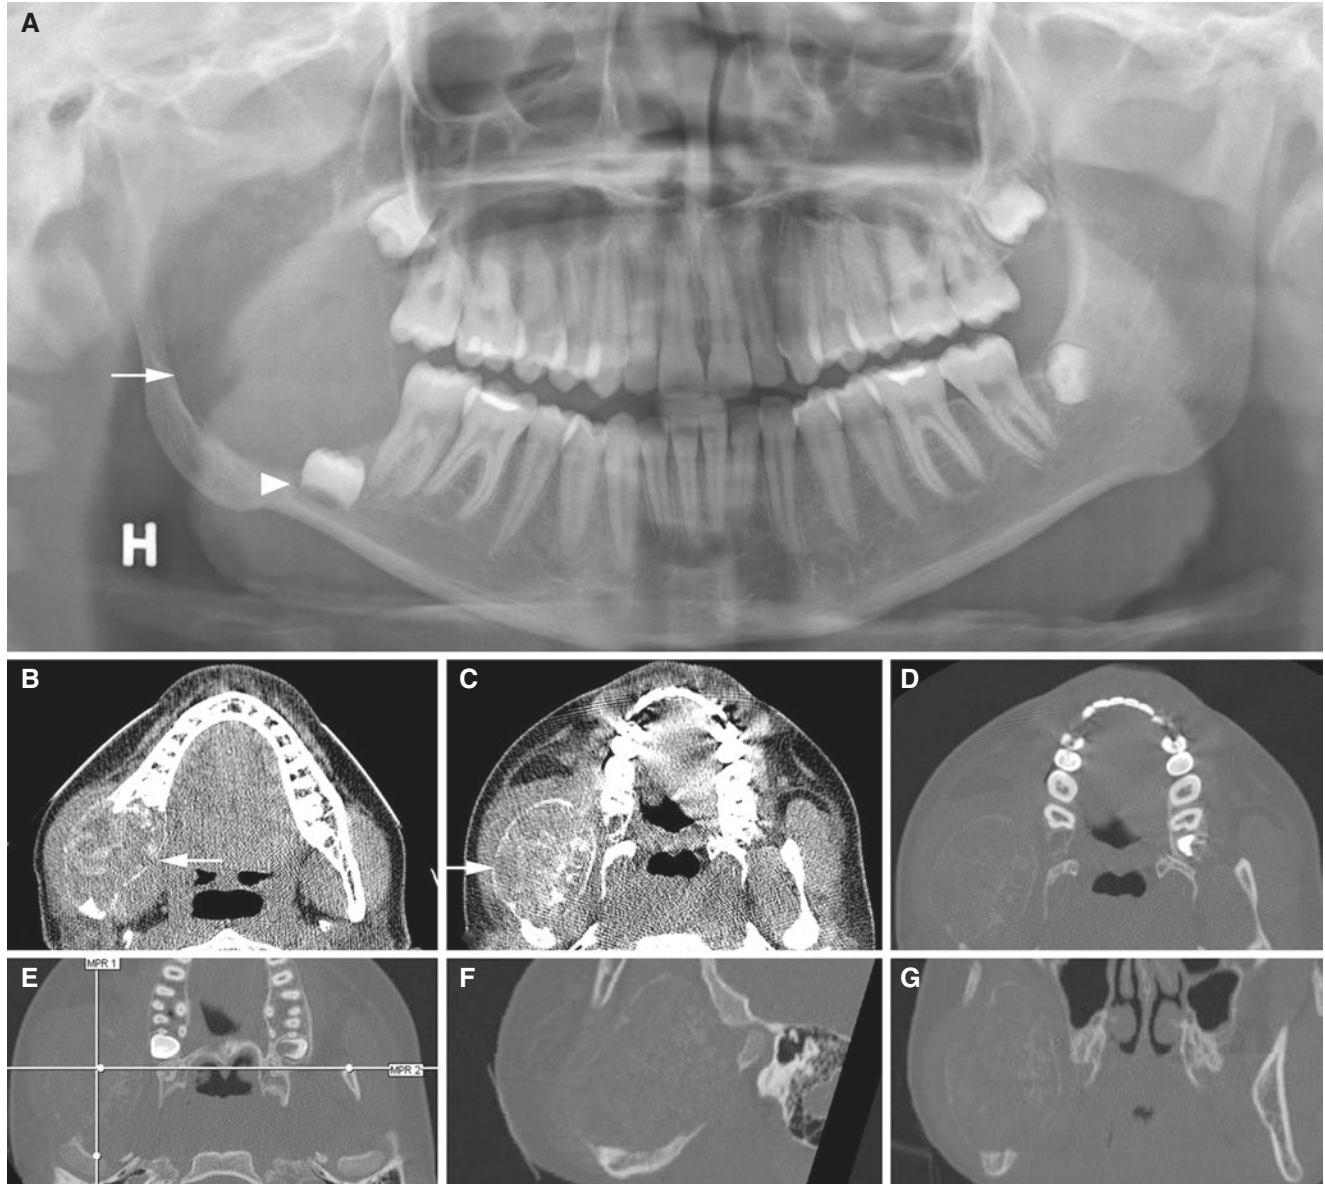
Juvenile ossifying fibroma, mandible; 13-year-old female with pain-free swelling of the right mandible. (A) Panoramic view shows radiolucency in the right mandibular ramus (*arrow*) and displaced tooth germ (*arrowhead*). (B, C) Axial (soft-tissue window) CT images show expansive mass with rather well-defined and thinned
